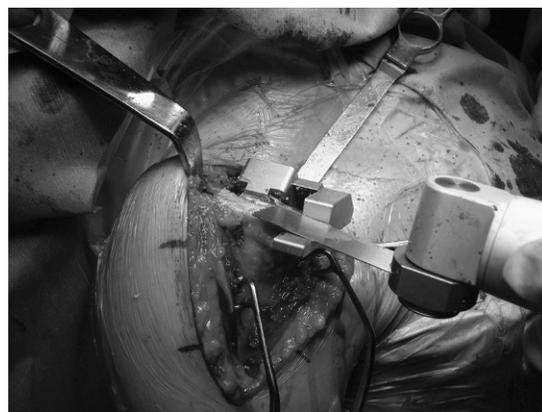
If a DePuy CTA prosthetic (DePuy, Johnson and Johnson) is used, then the tuberosity osteotomy is made using the supplied cutting guide.
